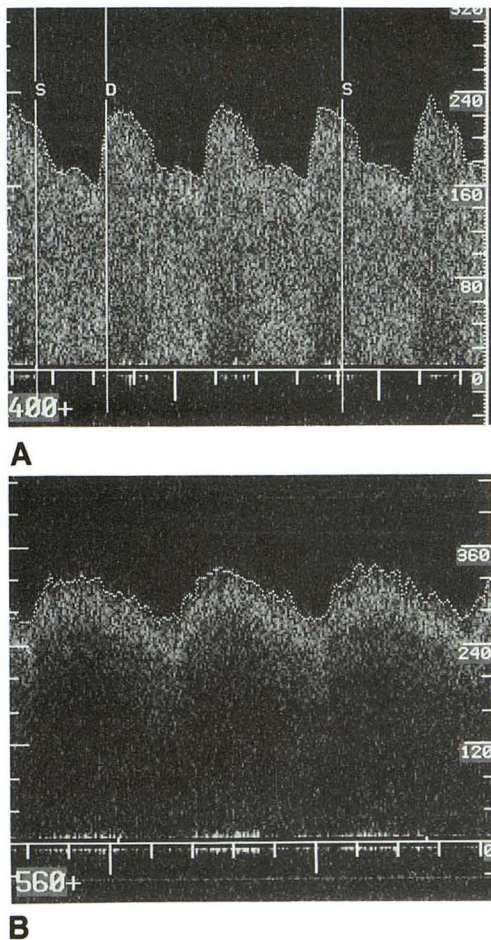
A, Example of detection of disturbance in laminar blood flow in an arteriovenous fistula model by spectral broadening in the Doppler guide wire spectra.
